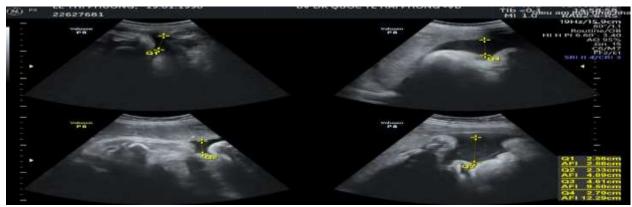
Ultrasound image of the fetus upon admission to the hospital
